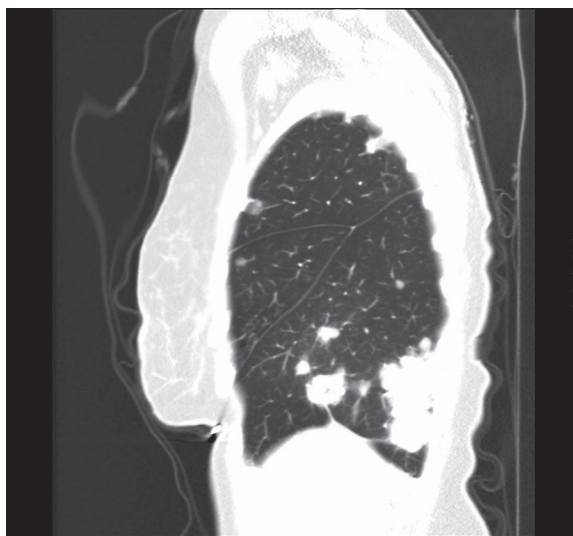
Chest CT. Multifocal alveolar infiltrates.
